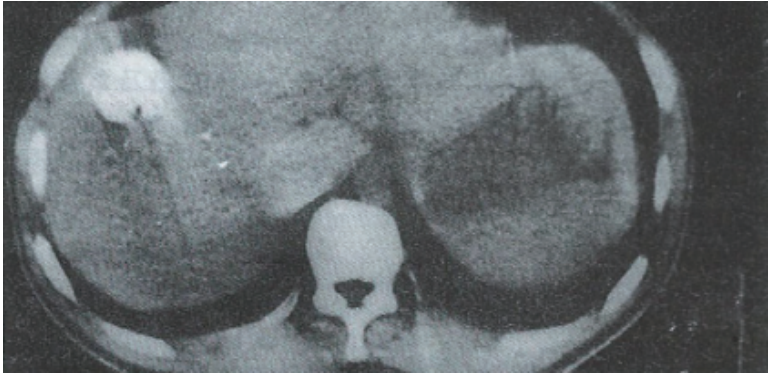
Nine months after HAE, a CT scan of this patient showed obvious tumor shrinkage and Lipiodol retention in the tumor area.
